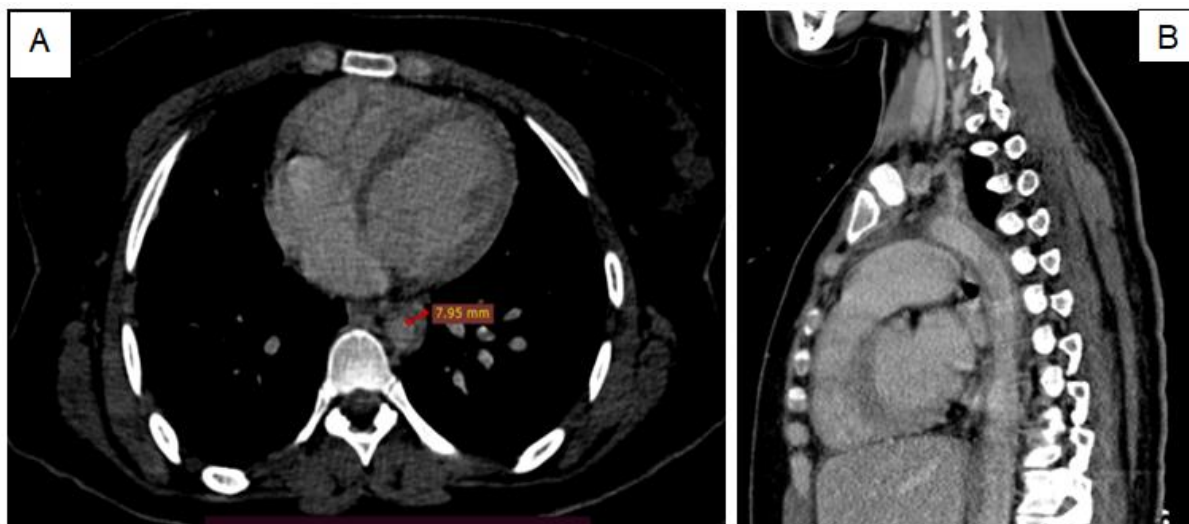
Cervicothoracic CT scan in axial (A) and sagittal (B) sections reveals diffuse mural thickening of the aortic arch and descending aorta, measuring a maximum thickness of 8 mm. This thickening is non-enhanced following the injection of the contrast medium (PDC) and is noted at the level of the supra-aortic trunks
